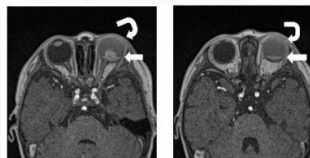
(left) and (right) Axial T1-weighted MRI images of a 13-month-old boy with retinoblastoma of left eye. There is a T1-weighted hypointense layer (arrow) in the dependent region of vitreous humour of left eye, with diffuse increase in T1-weighted hypointense signal in rest of its vitreous humour (curved arrow) when comparing with contralateral eye. Features are suggestive of vitreous hemorrhage.
